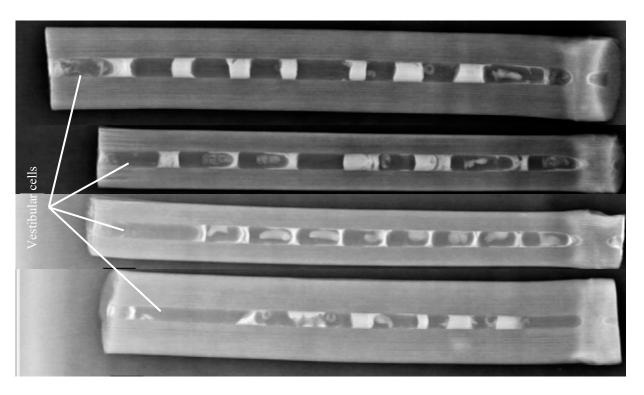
X-ray photographs showing four nests of Megachile cephalotes. Nest entrance is at the left.
